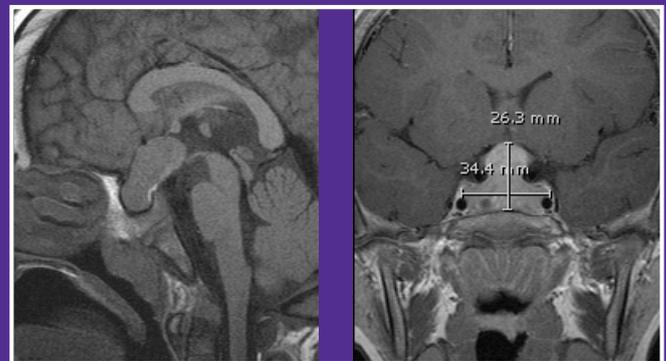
Magnetic Resonance Images of her macroadenoma arising out of an expanded pituitary fossa with significant suprasellar component. The sagittal view is presented in the left panel and the coronal view the right panel. Diagnostic images are reproduced with parental permission.
